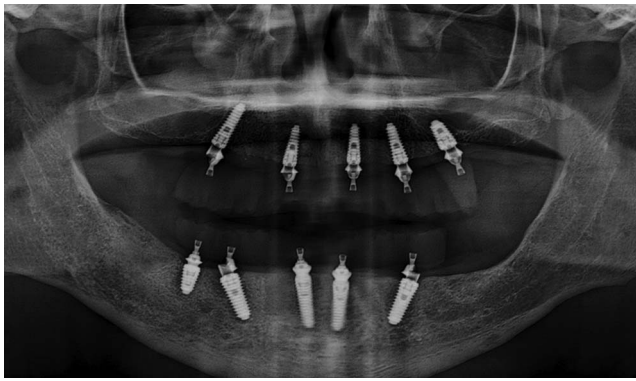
A postoperative panoramic radiograph shows full-arch rehabilitation with 10 MegaGen AnyRidge implants—5 maxillary and 5 mandibular. Implant distribution was optimized to support immediate, full-arch, screw-retained provisional prostheses.
